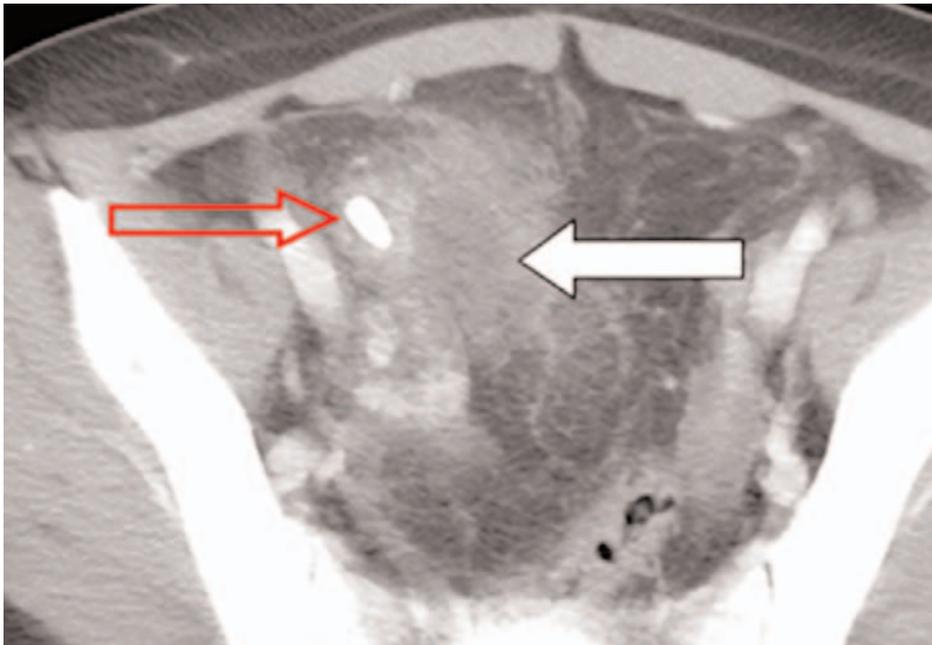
Acute appendicitis with appendicolith and abscess on CT. There is a large appendicolith in inflamed appendix (open arrow). Note small abscess medial to appendix (arrow). CT excels in demonstrating complications of appendicitis.
